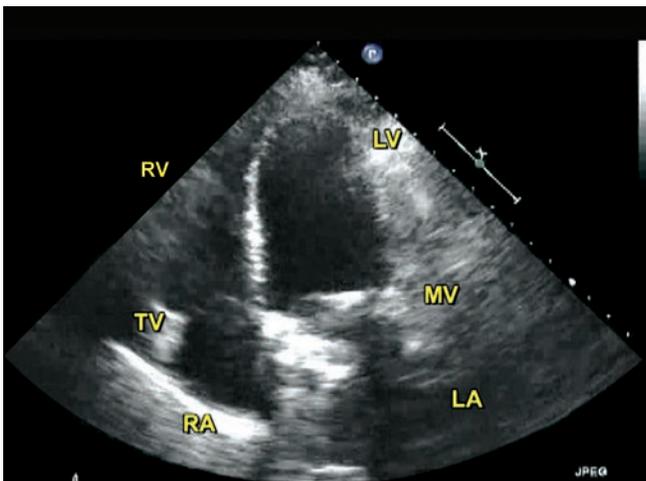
This image demonstrates a transthoracic echocardiographic apical four-chamber view of this patient with a prosthetic mitral valve. As is evident in this image, transthoracic echo can be limited in the diagnosis of prosthetic valve thrombosis given acoustic shadowing of the left atrium and poor image quality. (LA: Left atrium; LV: Left ventricle; RA: Right atrium; RV: Right ventricle).
